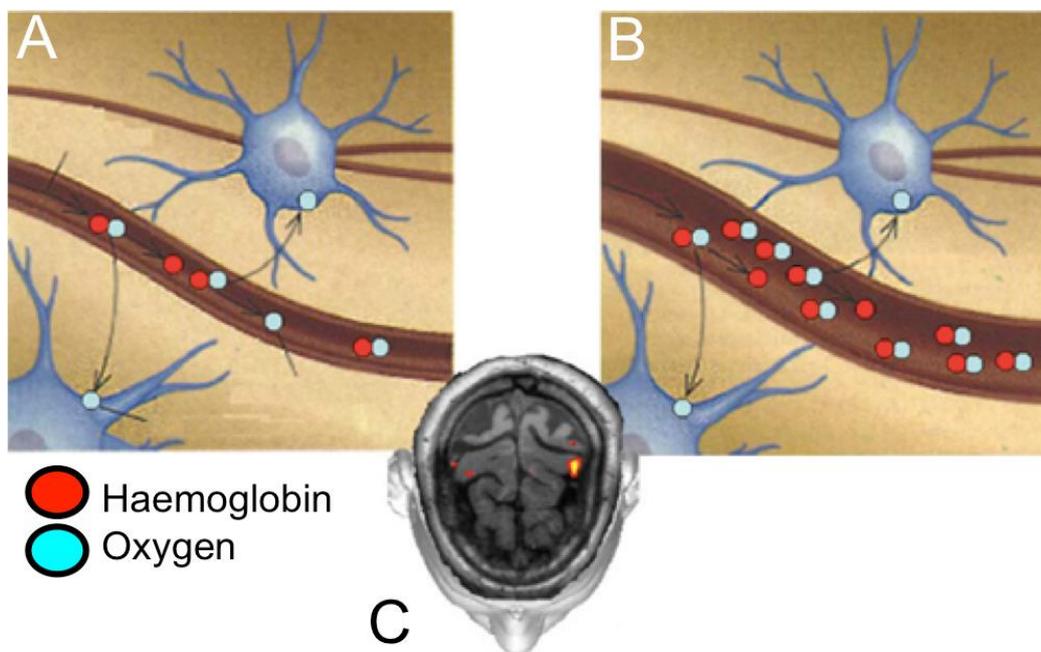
A) As neuronal activity increases, more oxygen is required. B) Blood flow increases to the areas of neuronal activity. C) Diamagnetic blood oxygen level dependent signal is measured by magnetic resonance imaging and computer processed in order to identify regions of increased neural activation (coloured highlights). Note. Adapted from (Astolfi et al., 2004).
